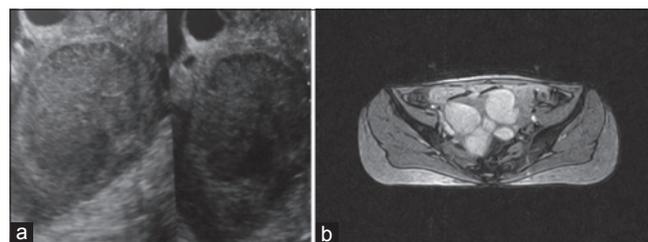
(a) Transvaginal sonography and (b) Magnetic resonance imaging pelvis showing bilateral endometriotic cysts
